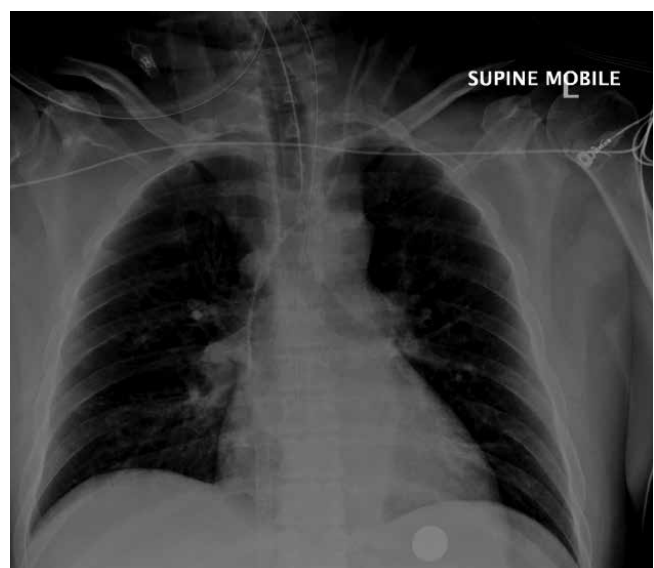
Mr GG's x-ray soon after extracorporeal membrane oxygenation showing the cannula introduced up the inferior vena cava, draining venous blood close to the right atrium.
